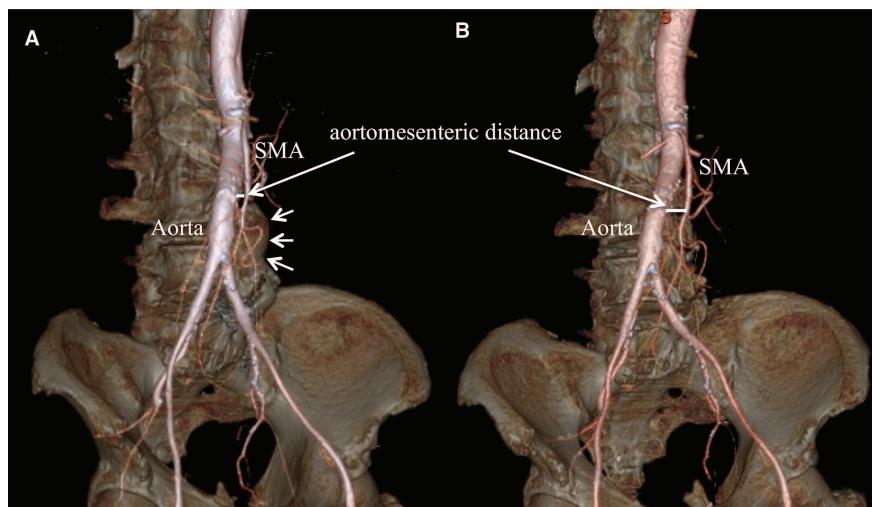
Preoperative (A) and postoperative (B) reconstructed 3-dimensional computed tomography scan showing the expansion of the aortomesenteric distance in the periphery. The arrows show the preoperative osteophytes. SMA, superior mesenteric artery.
